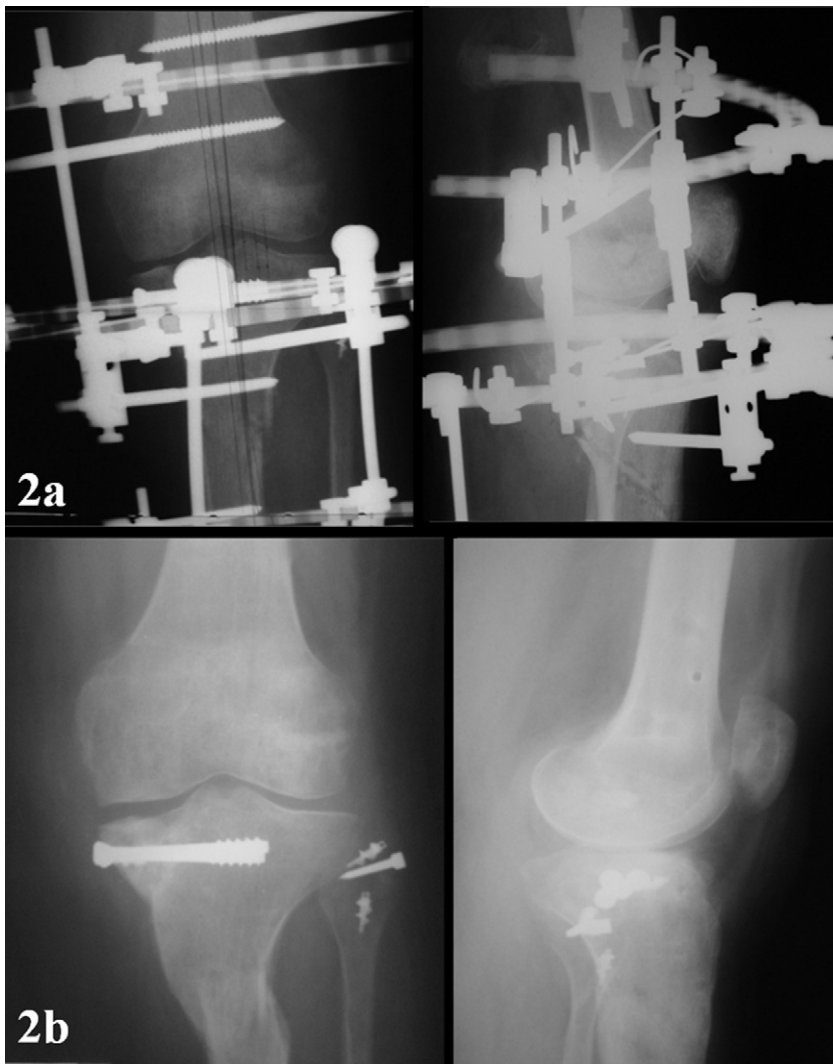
(a) Deformity correction with high tibial osteotomy and application of the circular external fixation. (b) Radiographic control in 4th month follow-up after removal of external fixator.
